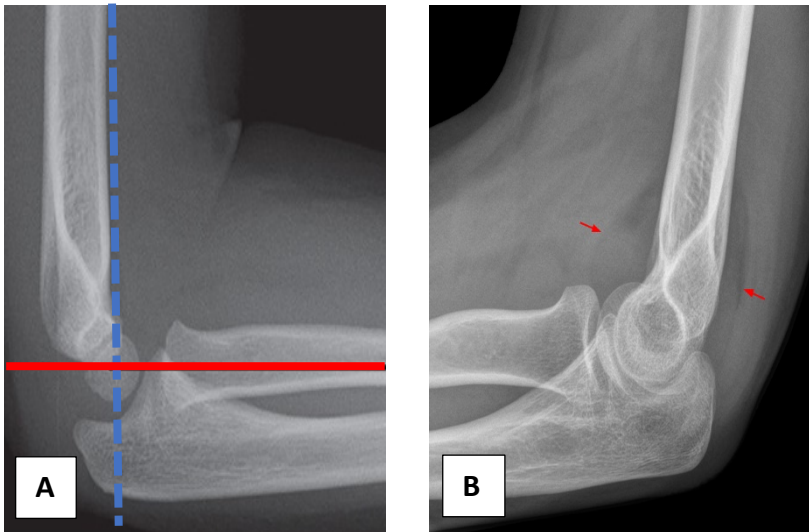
a) Lateral radiograph of an uninjured skeletally immature elbow. Red = radiocapitellar line, blue = anterior humeral line b) Lateral radiography of a skeletally mature elbow, demonstrating anterior and posterior fat pad signs. (Annotated original image from, Wikipedia, 2019)
